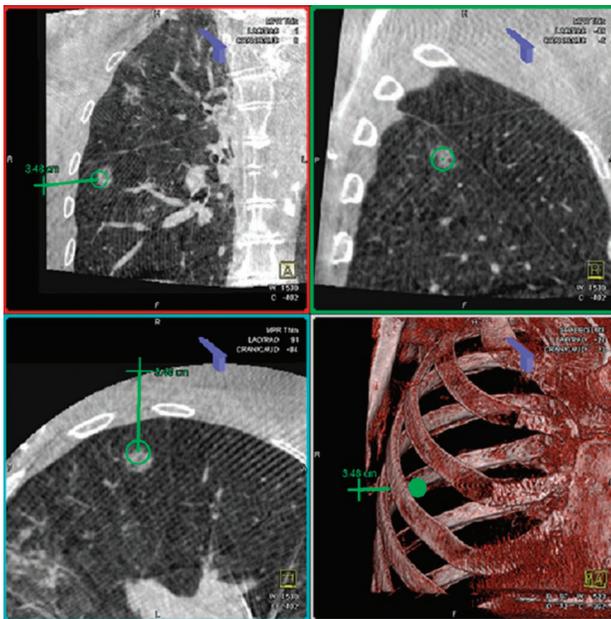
Intraoperative computed tomography localization with 3-dimensional reconstruction.
